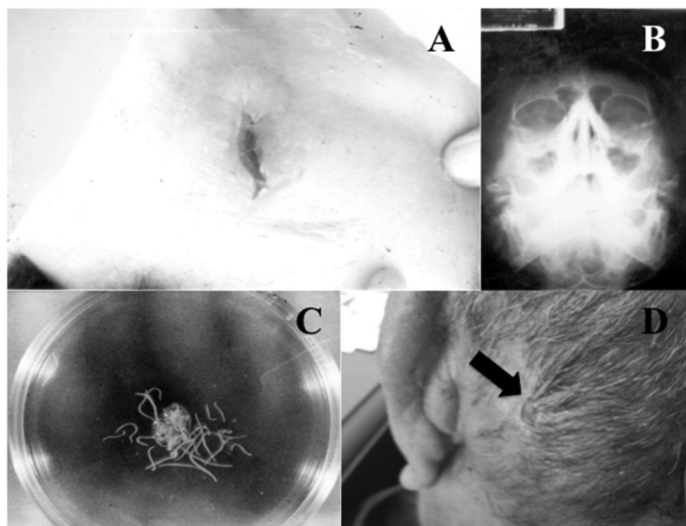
Different lesions caused by *Lagochilascaris minor* Leiper, 1909 in patients from the Yucatan Peninsula, Mexico. Fistulous lesion at the left submaxillary area (A). X-Ray showing sinusitis (B). *L. minor* parasites gathered from patient sinuses (C). Draining fistulous lesion at the left mastoid area (D).
